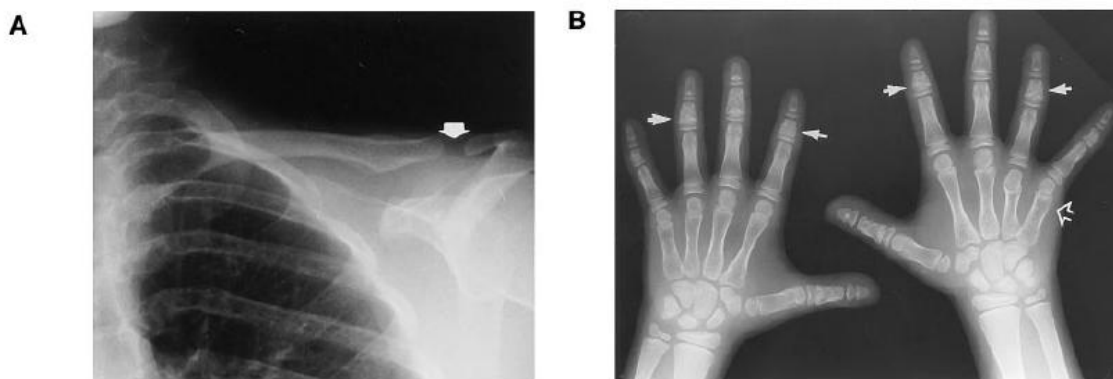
Radiographs of clavicle and hands of affected Individuals in family CCD [126].
